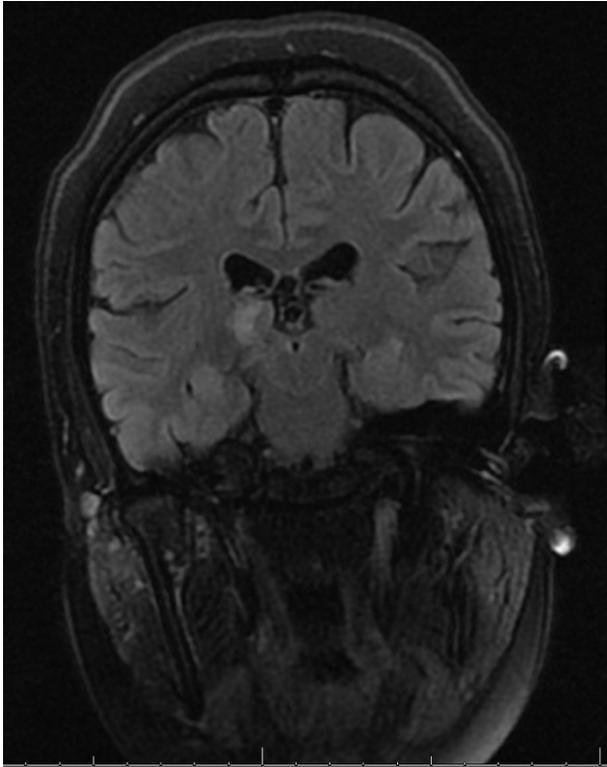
Five-month T2 FLAIR partial resolution post-rituximab infusion.
